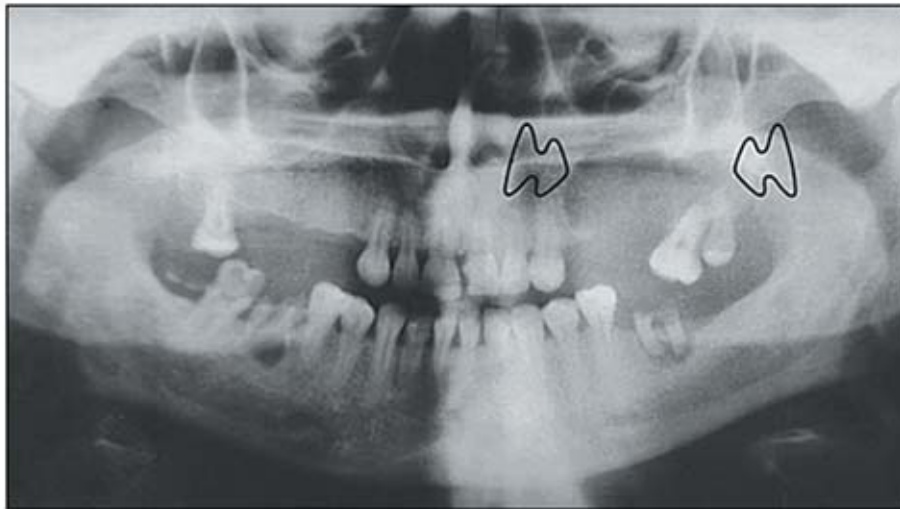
Preoperative orthopantomograph of the patient showing fine trabeculations within the lobular radiolucent tumor.
